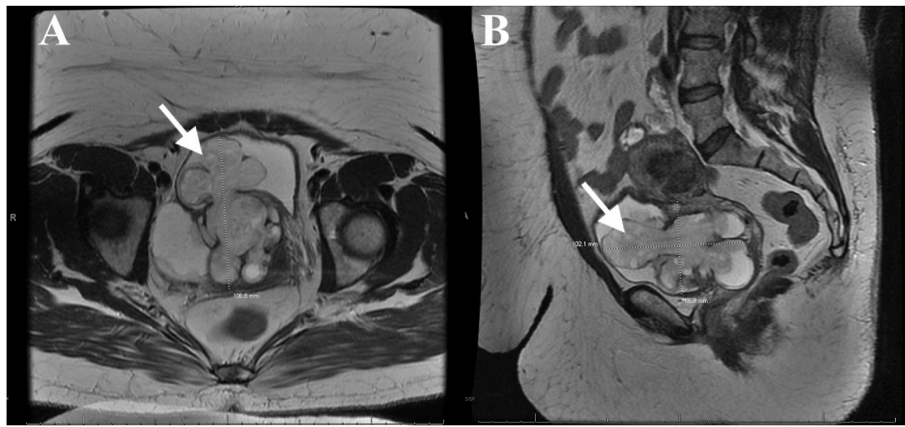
(A) Transverse and (B) sagittal T2-weighted MRI images demonstrating inflammatory myofibroblastic tumor of the urinary bladder (solid white arrow).
